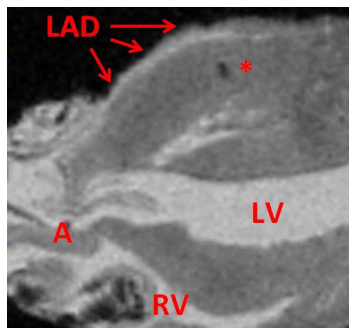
MRI revealed intact anatomy of fixed hearts (here with control MPIO) with left (LV) and right (RV) ventricular cavum, aortic valve (A) and left anterior descending artery (LAD) with hyperintense intraluminal contrast after perfusion with gadolinium. Sutures for fixation of the filter paper left intramyocardial defects ().*
